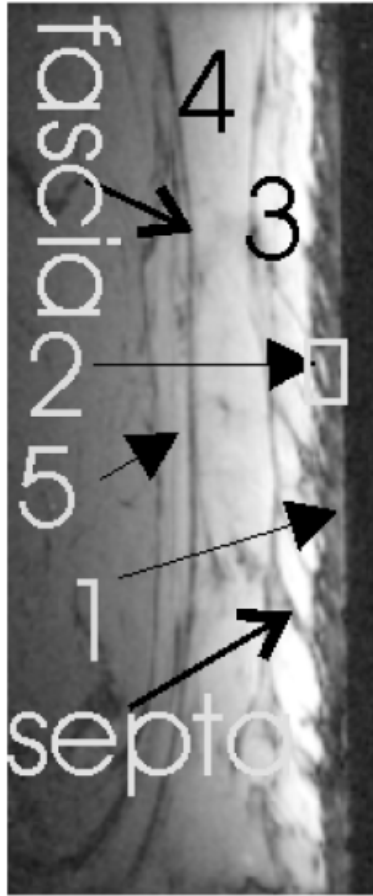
Typical MRI thigh skin. Right to left is the surface of the skin to muscle with a plane resolution of $273 \times 273 \mu\text{m}$. From right to left is the surface of the skin, Zone 1 is the dermis layer, and Zone 2 is the bright pixels shown in the box extrusion of hypodermic tissue inside the dermis. Zones 3–5 are the upper, middle, and lower parts of the hypodermis. Dark fibrous streaks separating fat lobules inside the hypodermis (fibrous septa) and fascia; the linear connective tissue connecting the deep fat layer of the skin to muscle is clearly visible in the image.
